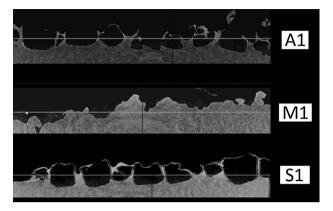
X-ray microtomography images of A1, M1, and S1 shells
